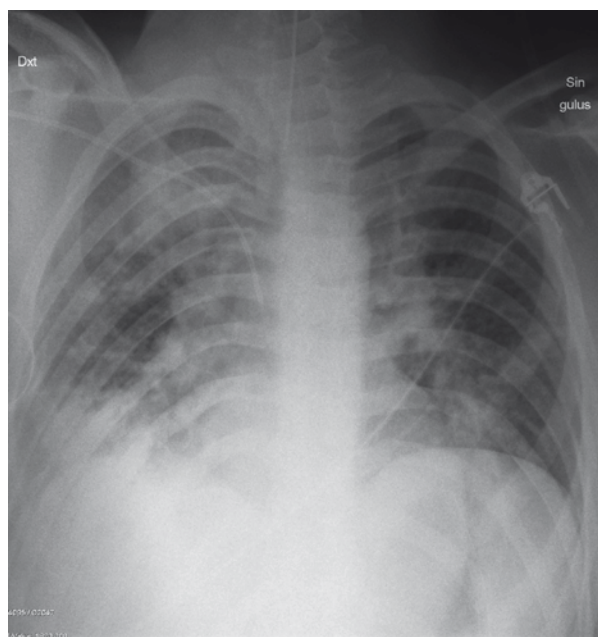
Chest X-ray on admission with multiple focal shadows on the both sides of the lungs and unilateral intensive infiltration in the middle part of the right lung that suggested the severe bilateral pneumonia
